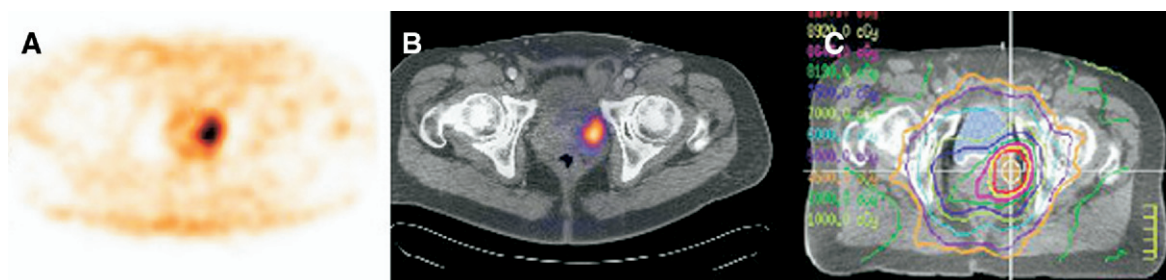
FCH-PET-guided radiotherapy. (A) The black area on this transaxial PET image corresponds to increased FCH uptake in a malignant tumor situated in the left lobe of the prostate gland. In an experimental treatment plan, this PET-defined biological target volume (BTV) will be prescribed a radiation dose of at least 90 Gy. (B) A “fused” PET/CT image is used to plan the radiation treatment. In this patient, the prostate volume was 62 mL and the BTV volume was 14 mL. (C) The experimental treatment plan is summarized by colored lines corresponding to prescribed iso-doses of radiation. Doses of 91 Gy and 76 Gy were prescribed to the BTV and prostate, respectively, without significantly increasing radiation exposure to un-involved organs (rectum and bladder).
